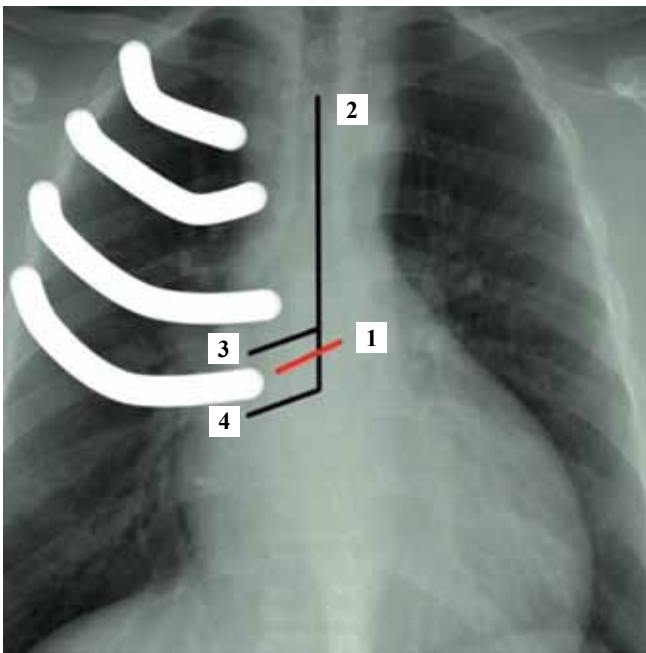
Chest X-ray in a direct projection: (1) aortic root projection, (2) sternotomy line, (3) intersection of the sternum through the 3rd intercostal space, (4) intersection of the sternum through the 4th intercostal space. The white areas indicate the position of the ribs
